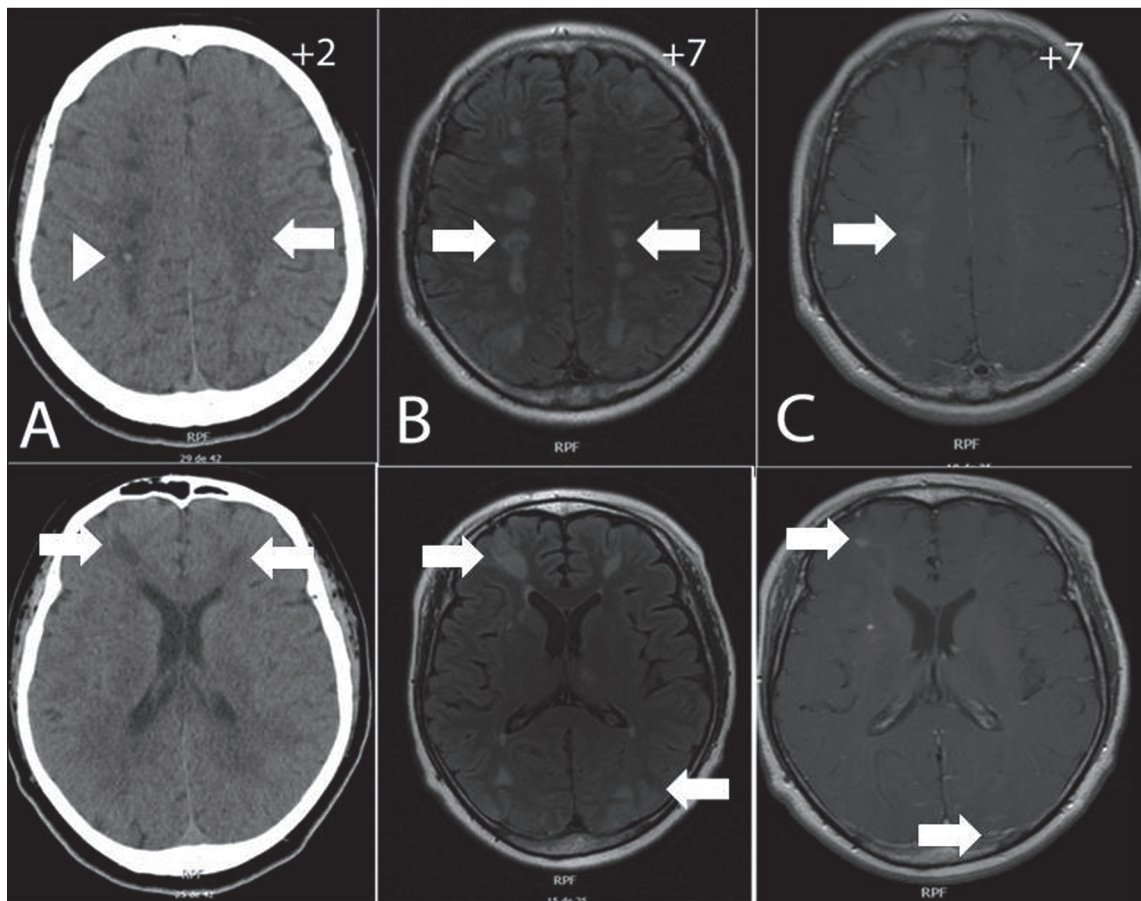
A: (Upper and lower figures): Brain CT images without contrast media obtained at 2 days post admission. Hypodense lesions are observed within semioval centers (arrow, upper figure) and in subcortical frontal areas (arrows, lower figure). Minor hemorrhagic points are also present (arrowhead in upper figure) that were corroborated by GRE T2-weighted MR sequence (not shown). B: (Upper and lower figures) FLAIR (*Fluid-Attenuated Inversion Recovery*) MR brain images in axial projection at 7 days post admission. Hypertense signals are observed in semioval centers (arrow, upper figure) and in frontal and occipital cortical-subcortical areas (arrows, lower figure). C: T1 signal in axial projection of brain MR with gadolinium (Gd, paramagnetic contrast). Gd-enhanced lesions are observed in semioval centers and in frontal and occipital areas (arrows). Images obtained at 7 days after admission.
